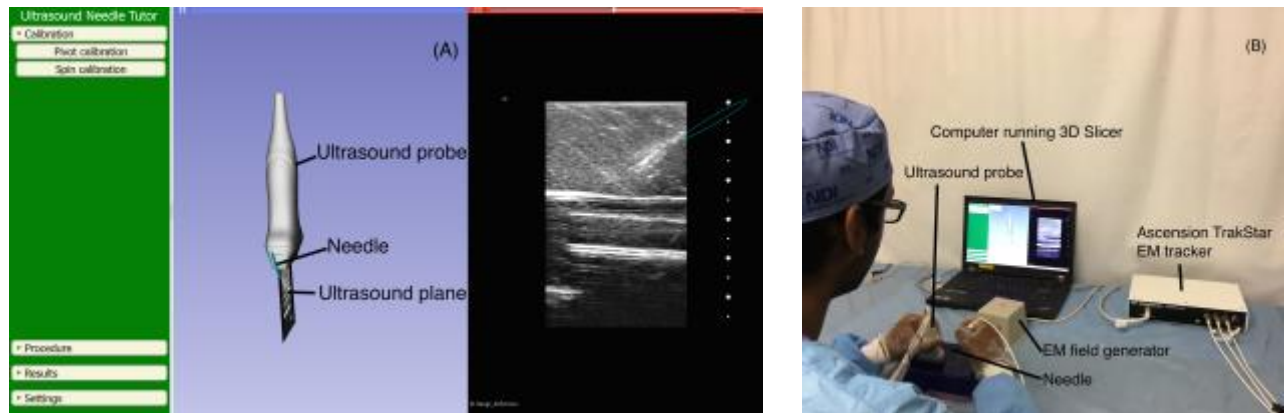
(A) Screenshot of Perk Tutor 3D visualization and ultrasound image. (B) Experimental training setup with novice practicing an in-plane needle insertion.
